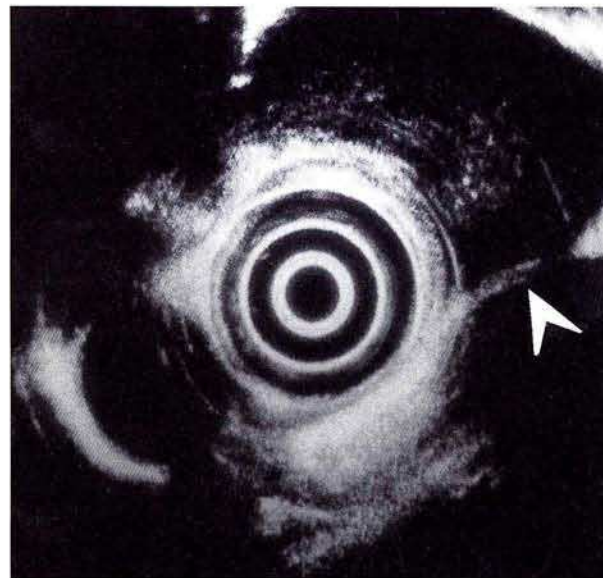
Endoscopic ultrasound image of the lesion.
